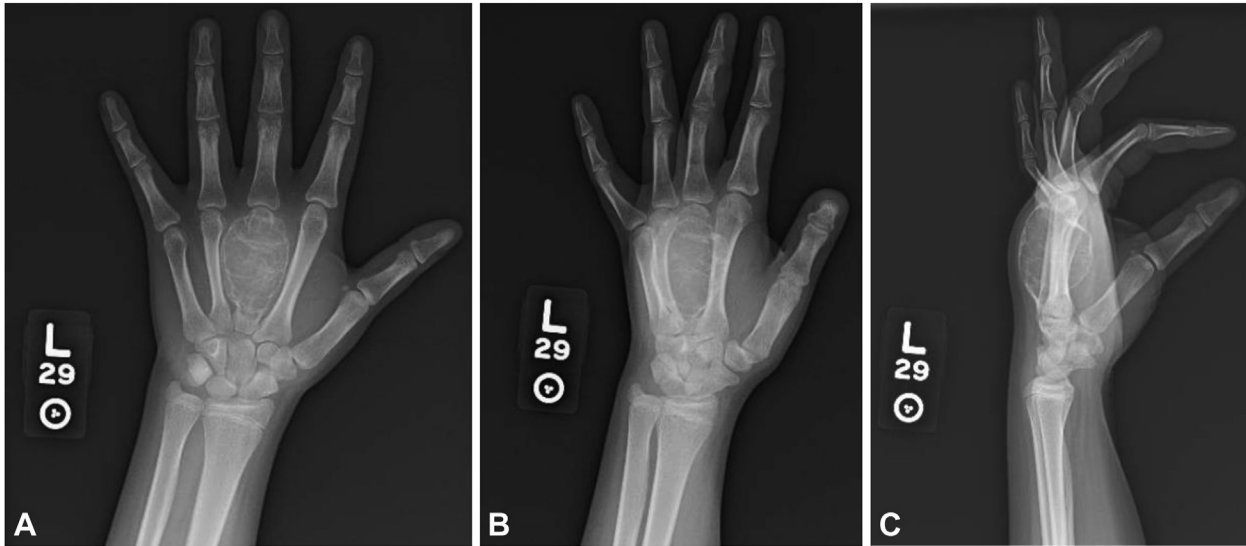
Presenting posteroanterior, oblique, and lateral radiograph of the left hand demonstrating a lytic third metacarpal lesion with cortical expansion and thinning measuring $4.5 \times 2.9 \times 3.3$ cm.
